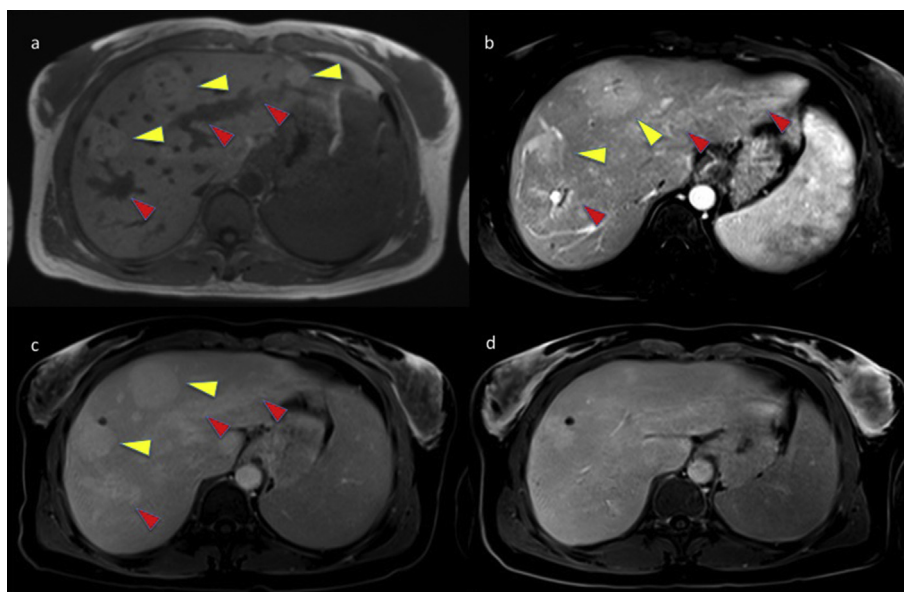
Liver MRI (A–D). A, T1w 2D-GE sequence showed hypointense periportal fibrosis (red arrowheads) with hyperintense regenerative nodules (yellow arrowheads) around the periportal space; B–C, T1w 3D-GRE sequence (VIBE) showed a marked enhancement of periportal fibrosis and regenerative nodules in the late arterial and venous phases; D, no pathological hypointense lesions were detected in the hepatobiliary phase.
